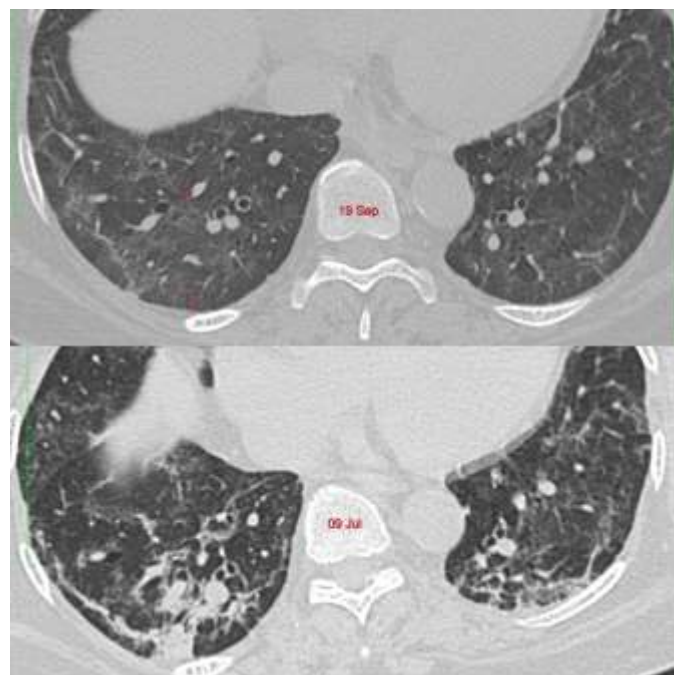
This 74-years old individual had a CT scan 1 month after her COVID-19 diagnosis showing consolidation and thick bands in the lower lobes. 10 weeks later, the lesions have resorbed with a residual "melted sugar" appearance.
